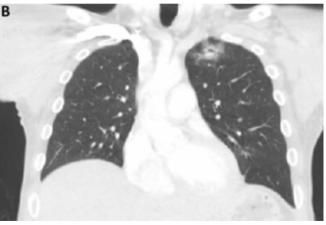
A) Chest X ray 6 weeks post chest tube and long term intravenous antibiotic therapy. B) Coronal Chest CT set to lung window showing a healing cavitary lesion in the right upper lobe, with resolution of the subcutaneous emphysema and pneumomediastinum.
